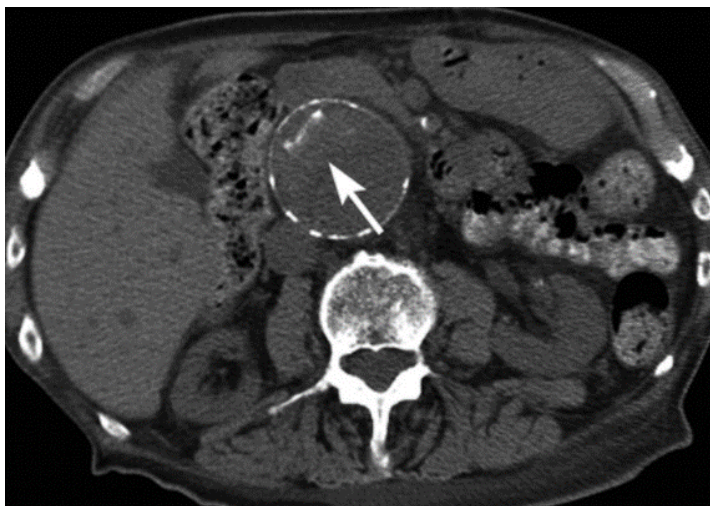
Unenhanced axial CT showing a hyperattenuating crescent sign (white arrow). Adapted from Rakita et al. (2) Authorized reproduction.
